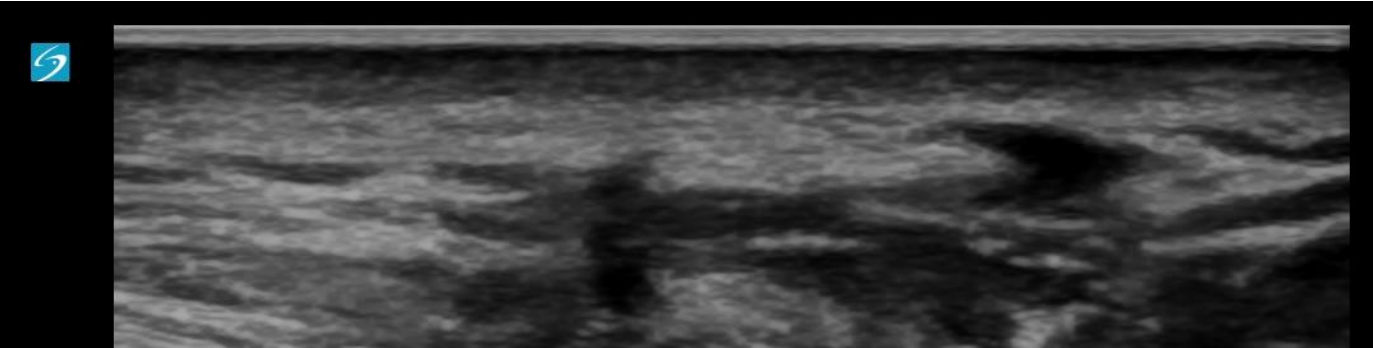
A. The ultrasound probe is positioned below the zygomatic bone and above the condylar notch on the lateral part of the face. B. The ultrasound image represents a sagittal view with the top of the image displaying the transducer. The bottom of the image, beyond the lateral pterygoid plate, is medial in orientation. The infratemporal fossa, which is the entrance into the pterygoid palatine fossa, is seen on the left of the image labeled anterior. The maxillary artery appears as a deep structure. C. The ultrasound beam travels from lateral to medial through the infratemporal fossa. LPM = lateral pterygoid muscle, arrows = needle trajectory, dashed circle = target area, MA = maxillary artery (color flow Doppler).
